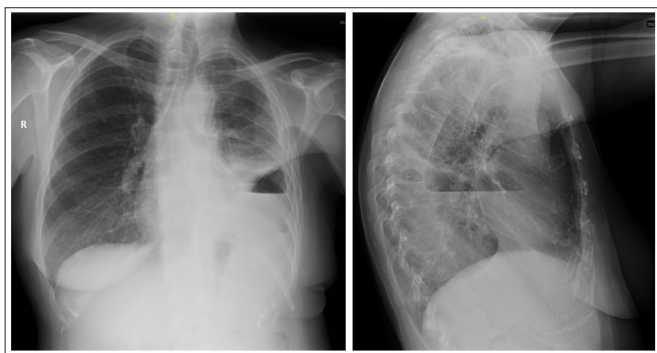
Chest X-Ray with Trapped Left Lung
